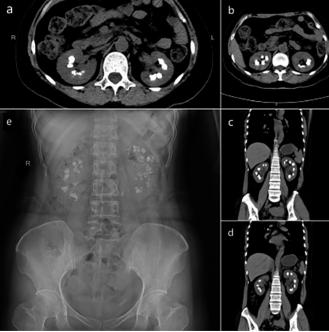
Computed tomography of urinary system shows multiple patchy high-density shadows in the bilateral renal sinusa, (a, b, c and d), abdominal X-ray shows multiple speckled high-density shadows in both renal areas (e).
